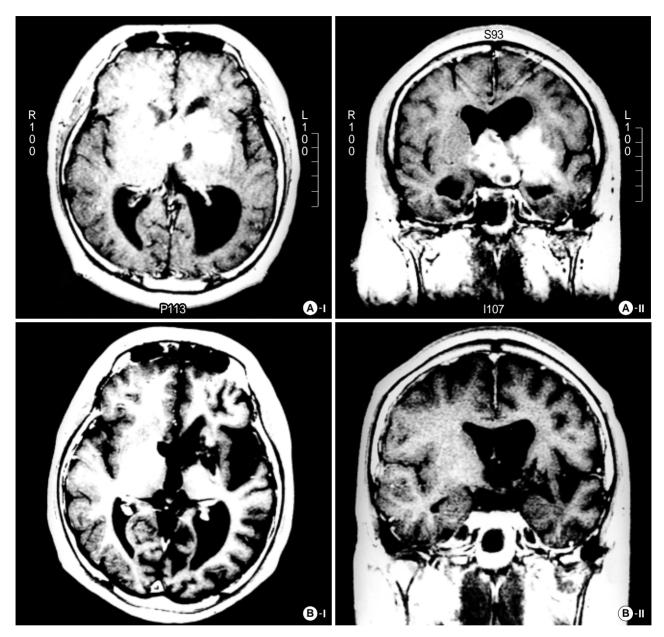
Brain MRI (A) at admission (1995.11.1). There is a large contrast-enhanced mass involving the optic chiasm, hypothalamus, thalami on the left side, and region of the foramen Monroe with extention to the septum pellucidum and anterior horns. (B) Follow-up MRI (1999.10.24) shows a complete resolution of the previously noted mass in the region of the left basal ganglia.
